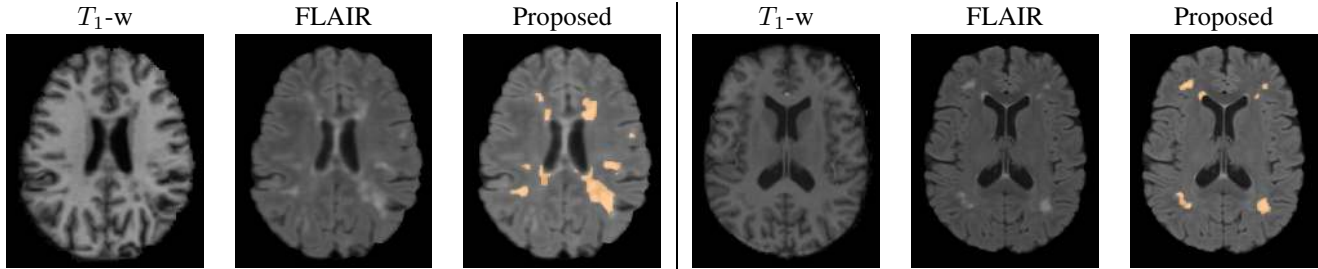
MICCAI dataset. Using the T_1 -w and FLAIR images, we obtain for the proposed method a lesion segmentation (shown in orange as overlay of the FLAIR image). The first three columns show the patient CHB15, and the others the patient UNC03 of the MICCAI MS challenge test dataset.
